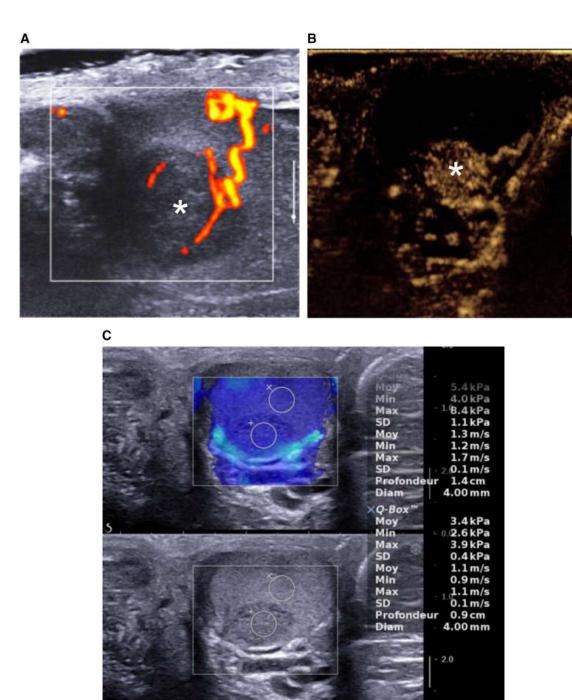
Non-palpable Leydig-cell tumor identified incidentally in a patient investigated for infertility. A Color Doppler US shows a vascularized hypoechoic testicular nodule (asterisk). B CEUS image obtained early after the arrival of microbubbles shows a hypervascular nodule with early enhancement
